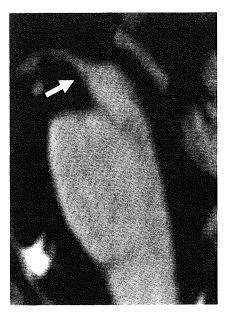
Progressive supranuclear palsy. A 74-year-old man. T1-weighted midsagittal image clearly shows atrophy of the midbrain tegmentum (*arrow*). The area of the midbrain tegmentum is 71 mm<sup>2</sup>.
